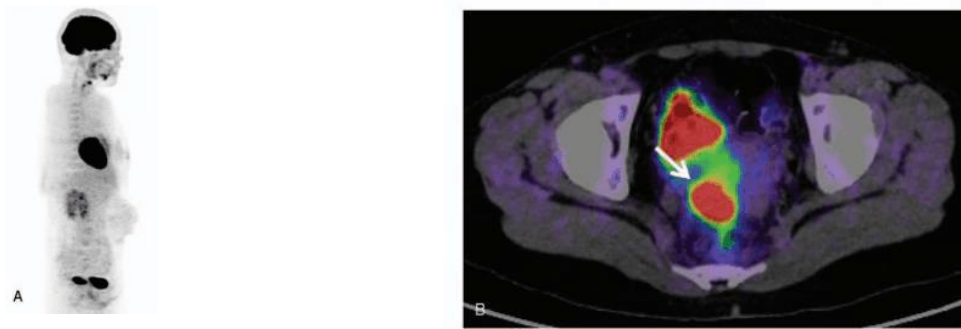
Positron emission tomography (PET) or computed tomography images of a patient with cervical cancer. (A) A typical whole-body 18F-fluorodeoxy-glucose (FDG)-PET image of a patient with cervical cancer. (B) A 32-year-old woman with stage IIA cervical cancer. FDG-PET images clearly show increased focal FDG accumulation (standardized uptake value = 22,43) in the tumor (arrow) [8]. The cancer cell consists of 3 parts called GTV, CTV, dan PTV [11]
